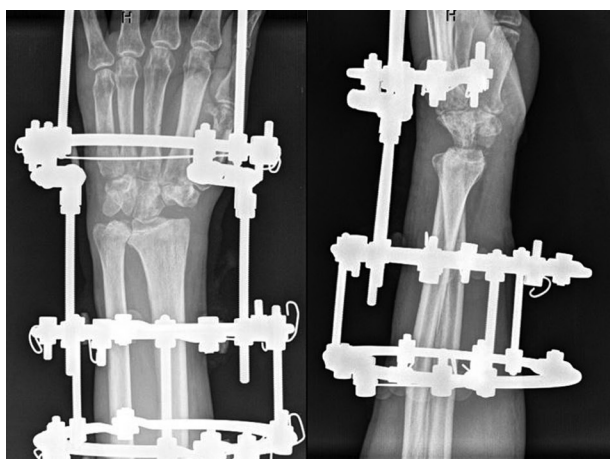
AP and lateral radiographs taken on day 1 post-surgery
